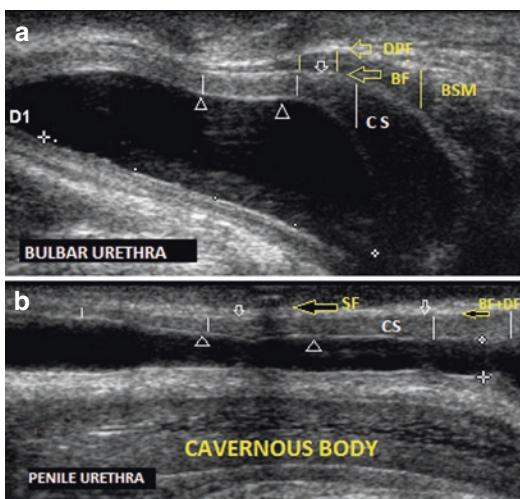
(a) Normal bulbar urethra ultrasound. *White bar*, CS corpus spongiosum; *yellow bars*, BSM bulbospongiosus muscle, DPF deep perineal fascia, SF superficial fascia; *white arrows*, BF buck fascia, urethral epithelium (arrowhead). (b) Urethral stricture with spongiofibrosis
